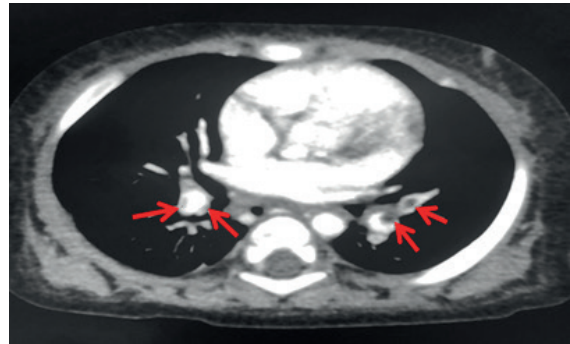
Pulmonary thromboembolism on computed tomography.
